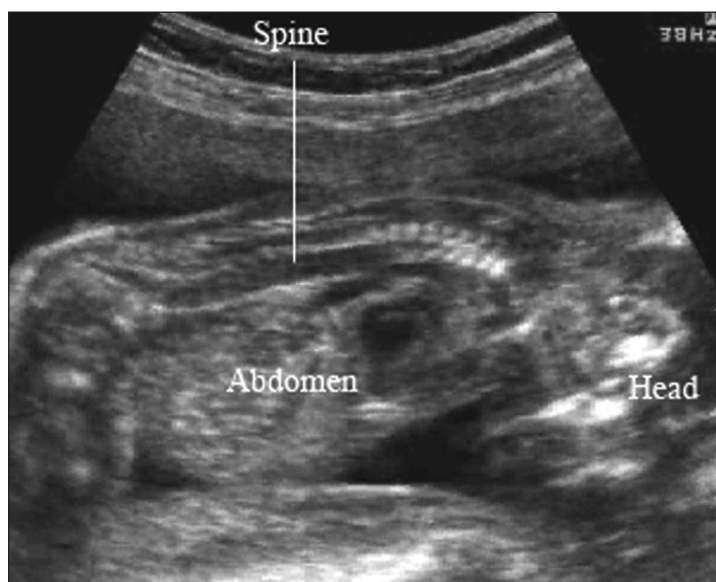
Sagittal sonogram of the spine showing markedly hypoechoic anterior bodies of the vertebrae.
